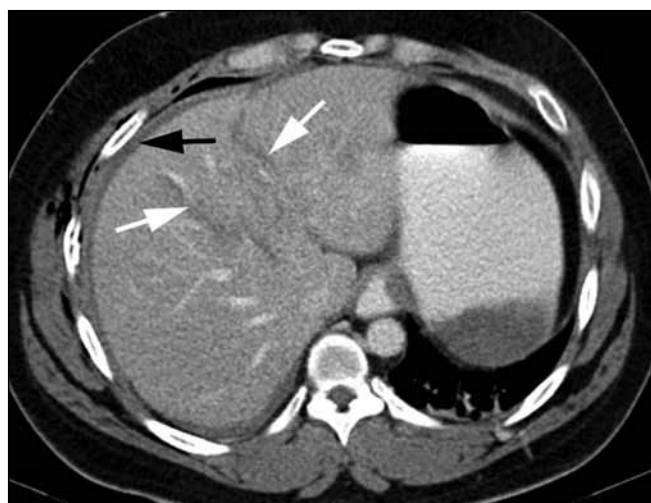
Axial CT of the abdomen at the level of the superior liver segments, in the same patient whose images appear in Fig. 3, shows a grade IV liver laceration (white arrows) with free fluid surrounding the liver.
